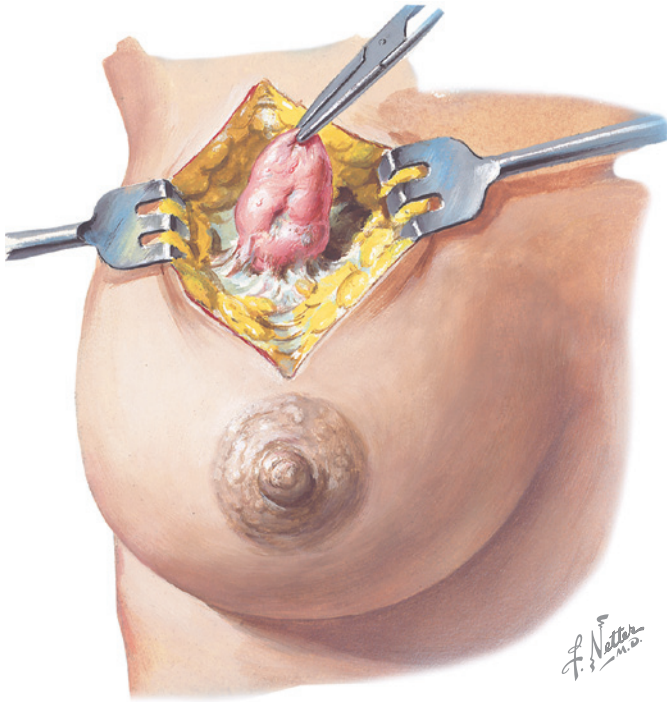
Open breast biopsy: masses are often not easily identified, requiring larger incision or needle localization using radiographic assistance.
